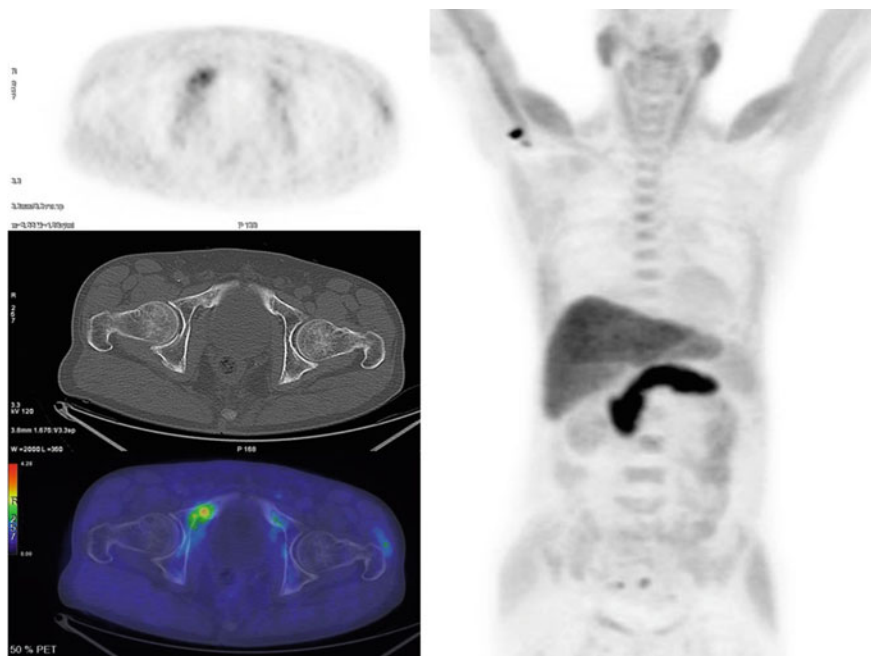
MIP image of ^{18}F -FACBC PET/CT (right-sided panel of the figure), with transversal images of the pathological bony lesion documented in a PCa patient with biochemical relapse after radical prostatectomy (PSA 4 ng/ml); note how the corresponding localization CT of the right pubic bone shows no significant alterations (*Courtesy of Dr. Cristina Nanni and Dr. Lucia Zanoni, University Hospital S. Orsola-Malpighi, Bologna, Italy*)
